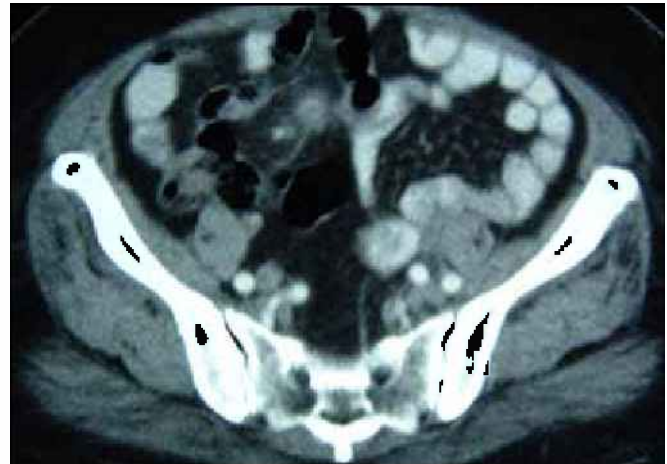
Abdominal CT image taken 21 days after starting antibiotics shows resolution of the pelvic mass in the left iliac fossa.
